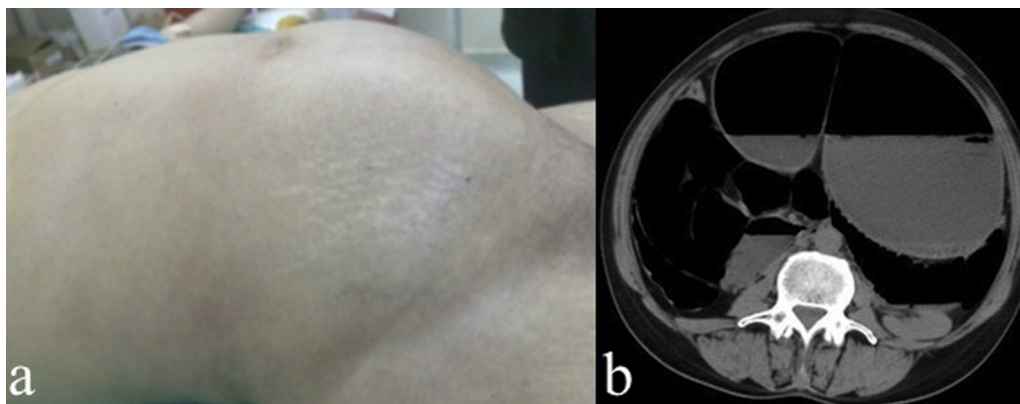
(a) Preoperative abdominal distention. (b) Abdominal CT; the stomach: severe dilated and volvulus axis where located at the distal 1/3 part.
